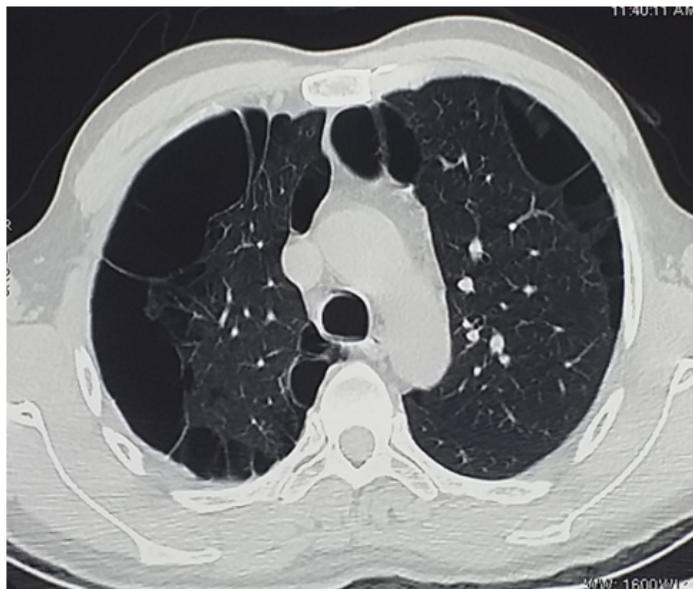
Computed tomography scan: pulmonary emphysema.
